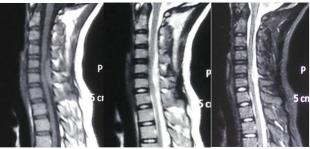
3 T1, T2 and lipid suppressor MR images of spontaneous spinal epidural hematoma
